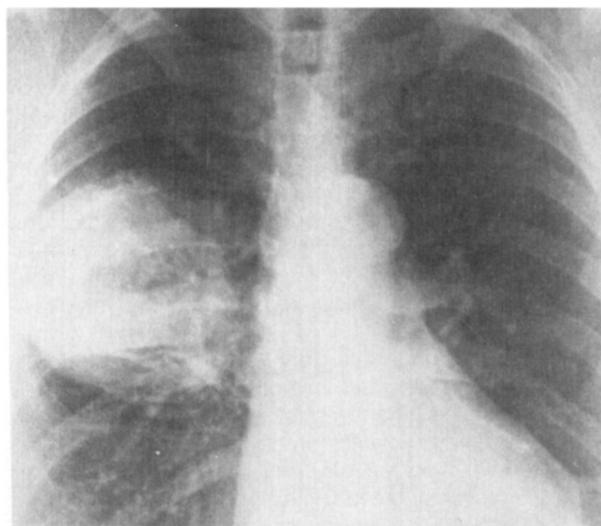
Chest radiograph shows large abscess in posterior segment of right upper lobe.
